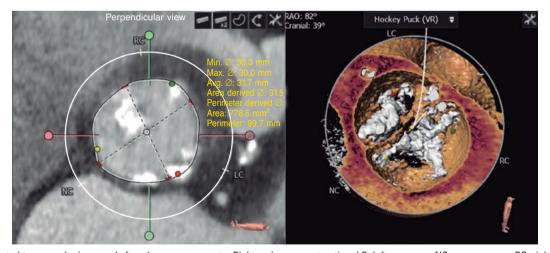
Computed tomography images. Left: valve measurements. Right: valve reconstruction. LC, left coronary; NC, noncoronary; RC, right coronary; VR, volume rendered.
